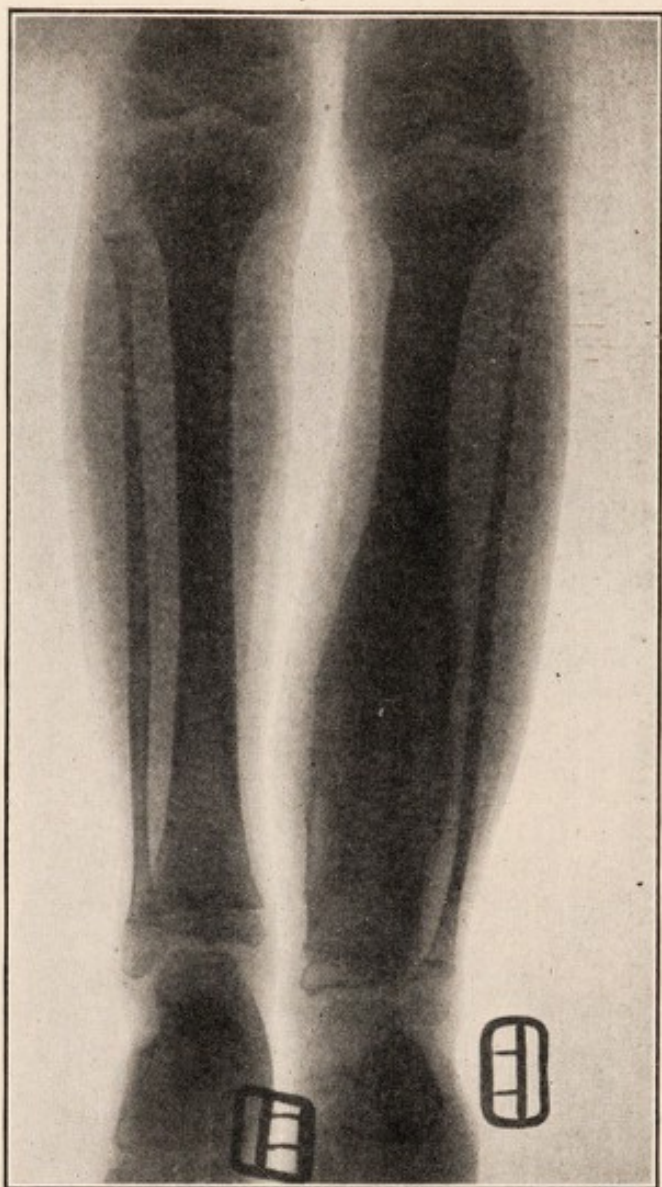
Osteomyelitis of tibia producing swelling and muscle spasm at ankle. Diagnosis plain from X-ray.
